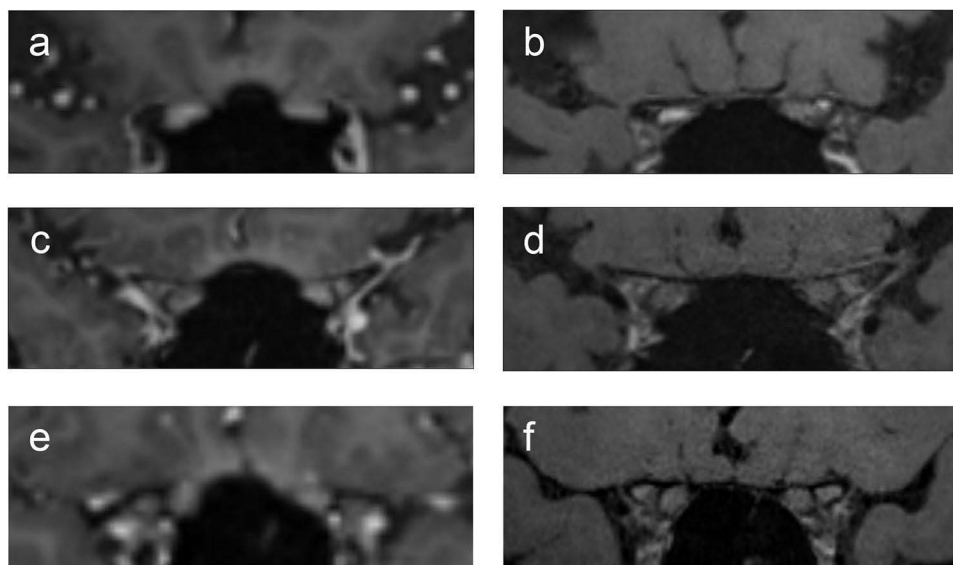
Representative magnetic resonance images of optic neuritis in this study. (a and b) Coronal magnetic resonance imaging (MRI) scans of optic neuritis. (a) Volumetric interpolated breath-hold examination (VIBE) scan shows no clear difference between the right and left optic neurons. (b) Delay alternating with nutation for tailored excitation sampling perfection with application-optimized contrasts using different flip-angle evolutions (DANTE T1-SPACE) showing a high signal in the right optic neuron. (c and d) Coronal MRI scans of non-arteritic anterior ischemic optic neuropathy. (c) VIBE image showing contrasting effects on the left optic neuron. (d) DANTE T1-SPACE showing no difference between the right and left sides. (e and f) Coronal MRI scans of optic neurons without abnormalities. (e) VIBE image showing high signals in the blood vessels around the bottom of optic nerve. (f) DANTE T1-SPACE suppressing the signal of blood vessels.
